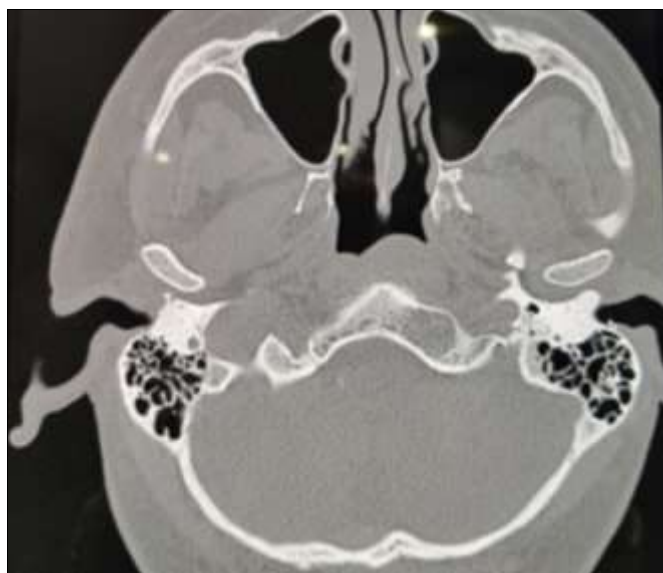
CT scan showing a hypo dense fat density lesion in the clivus.
